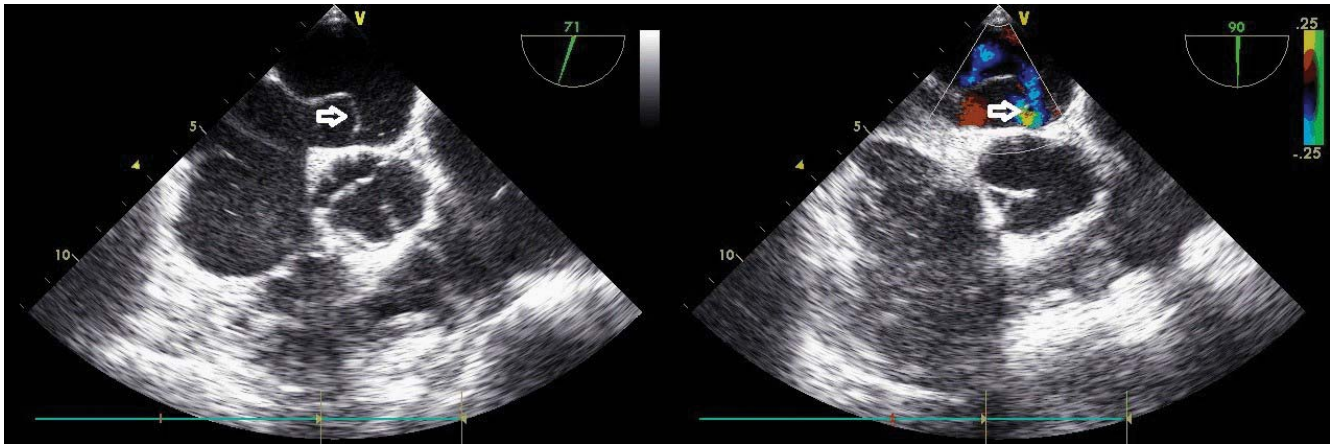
Transesophageal echocardiography. Left: interatrial septum aneurysm (arrow); Right: permeable foramen ovale with a small right to left shunt (arrow).
